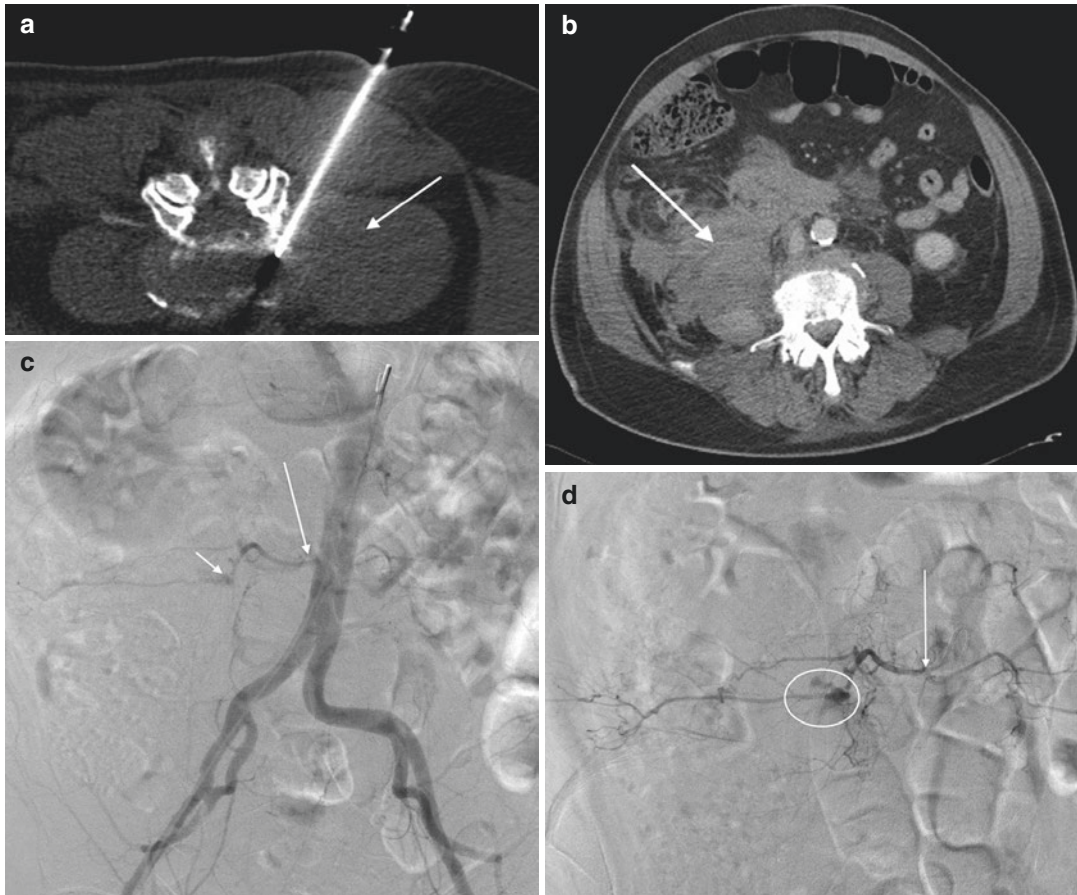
Expanding psoas hematoma following a lumbar disk biopsy in a patient with marginally corrected coagulation status (a). Axial CT image during the biopsy shows swelling of the right psoas muscle (arrow). (b). Follow-up CT of the abdomen shows expanding retroperitoneal hematoma (arrow). (c). Single frontal projection from aortic
